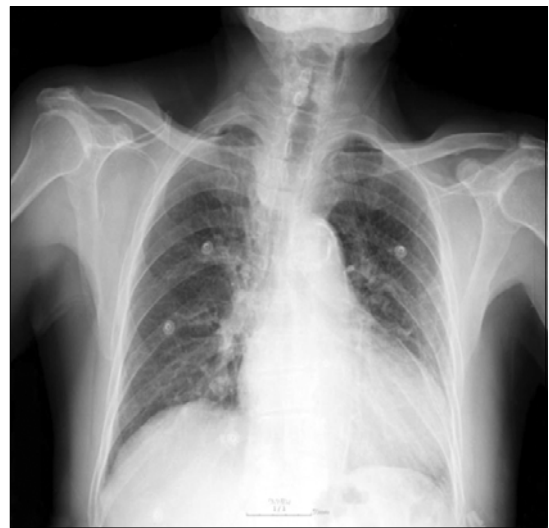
This figure shows the preoperative simple chest radiography.
